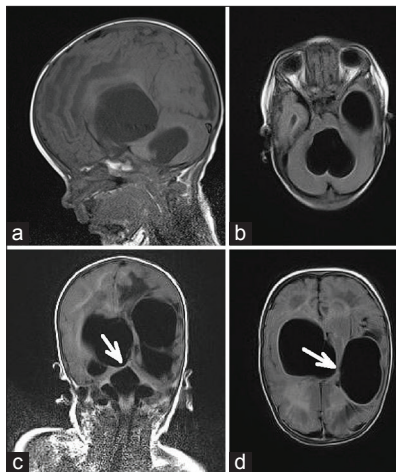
Case 2. (a and b) Magnetic resonance imaging of the brain before surgery showed the isolated cysts of the right and left hemispheres and IV ventricle. (c) The direction of the endoscope for perforation the rear cyst wall, which separated it from the IV ventricle. (d) After creation a fistula to the IV ventricle, the endoscope was returned into the cyst of the right hemisphere and the trajectory was changed in the direction to the cyst of the left hemisphere (the arrow)
